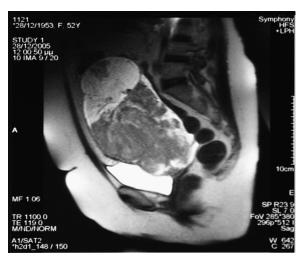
Magnetic resonance imaging (MRI) showing ovarian tumor of mixed feature.
